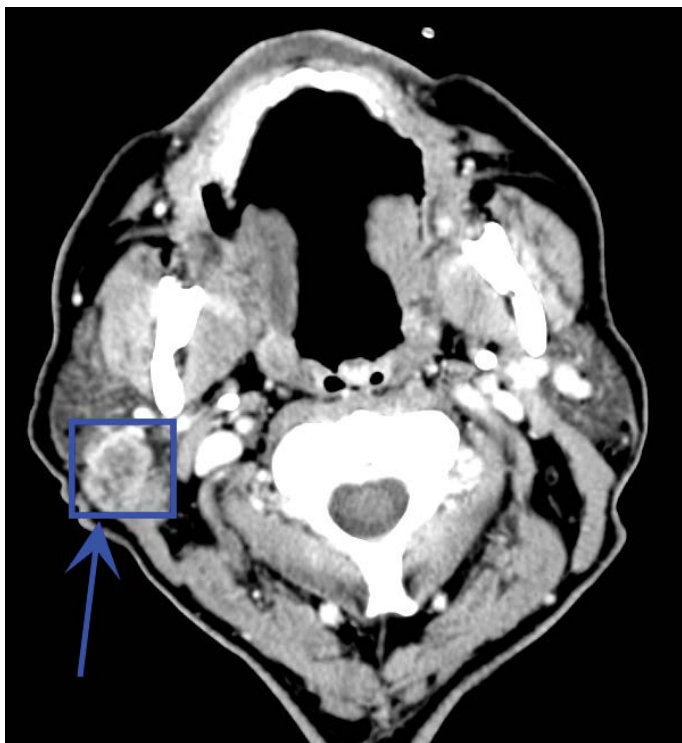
Pre-operative CT scan with contrast (axial plane) showing a 3 cm lesion of the right parotid with irregular margins and a necrotic center (blue arrow and square).
